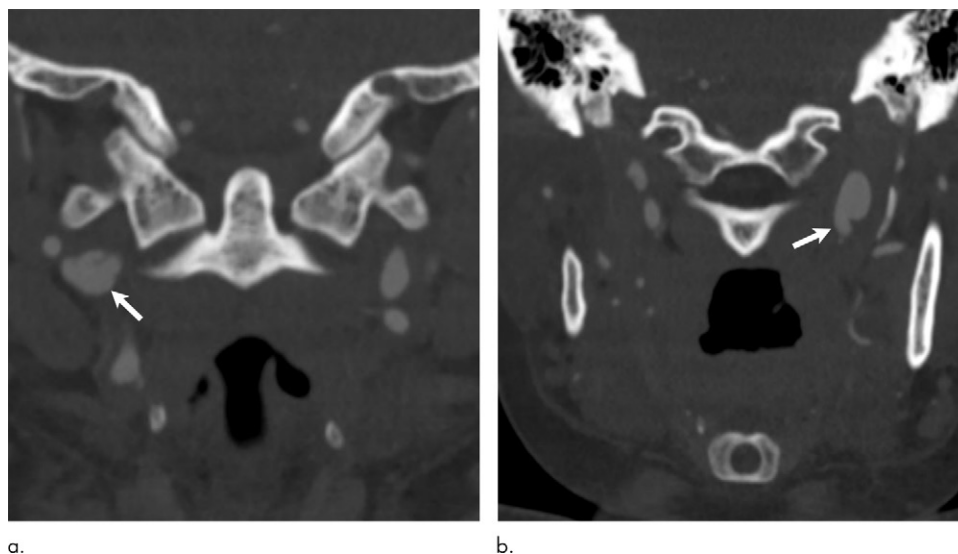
Coronal images from CT angiogram in the same patient as Figure 3 (42-year-old woman) show fusiform dilation of the (a) right and (b) left internal carotid arteries (arrow). Focal dissection of proximal right internal carotid artery is seen.
